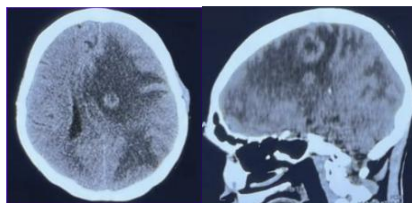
Axial and Sagittal slices of non-contrast head CT scan showing multiple metastatic lesions with significant perifocal edema causing midline shift to the right
